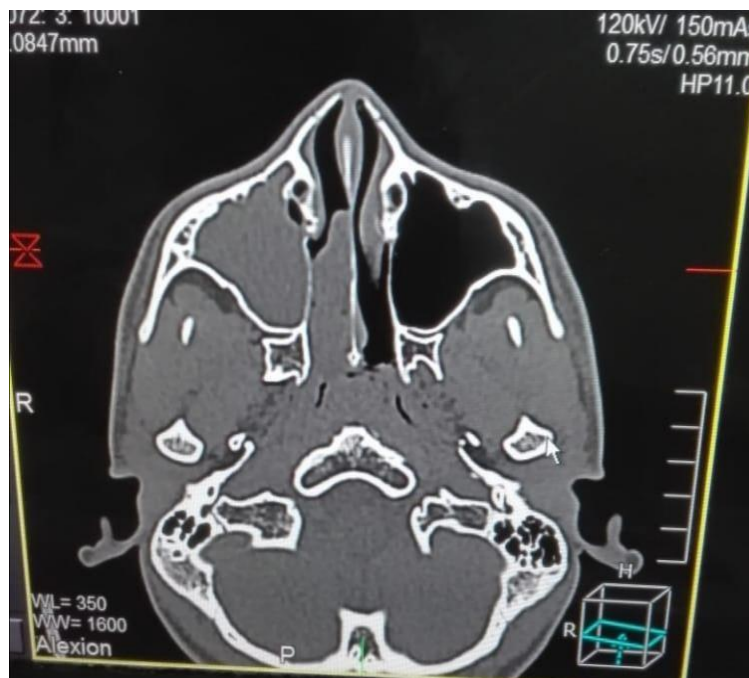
shows 43 years old female axial CT image with polyps in ethmoid and maxillary
